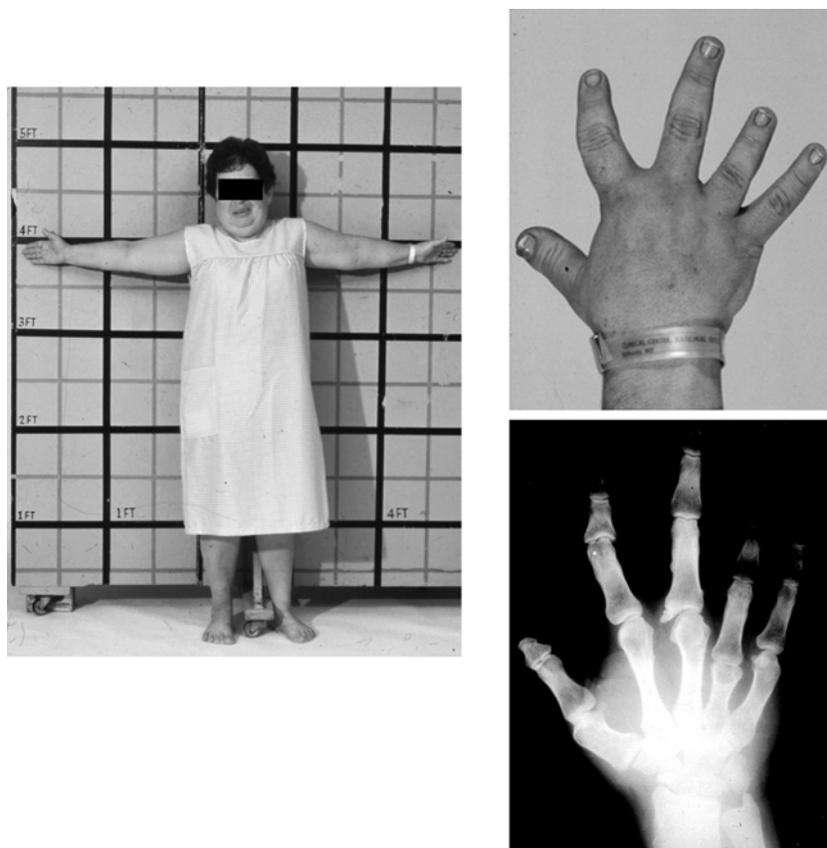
Albright hereditary osteodystrophy (AHO). (Left) AHO patient with short stature, obesity, and rounded face with depressed nasal bridge. (Right) Photograph (above) and radiograph (below) of hand with severe brachydactyly of the first, fourth, and fifth metacarpals. (Reproduced from Weinstein (2004) "Molecular Basis of Inborn Errors of Development," Oxford University Press).
